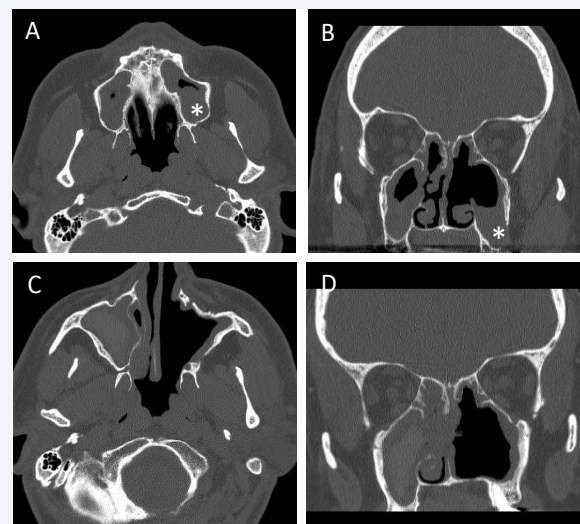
Case 1; (A) Axial view, (B) Coronal view; Pre-operative CT scan of left maxillary sinus AM measuring 3.8 x 2.4 x 1.0 cm present within inferior aspect of the left maxillary sinus with bony erosion at the posterolateral aspect of the maxillary sinus wall and into the left cheek; (*) denotes tumor soft tissue adjacent to eroded bone. (C) 15-month post-operative axial view of left maxillary sinus, (D) 15-month post-operative coronal scan left maxillary sinus shows no tumor recurrence in left maxillary sinus; opacification in the right maxillary sinus due to fungal rhinosinusitis.
